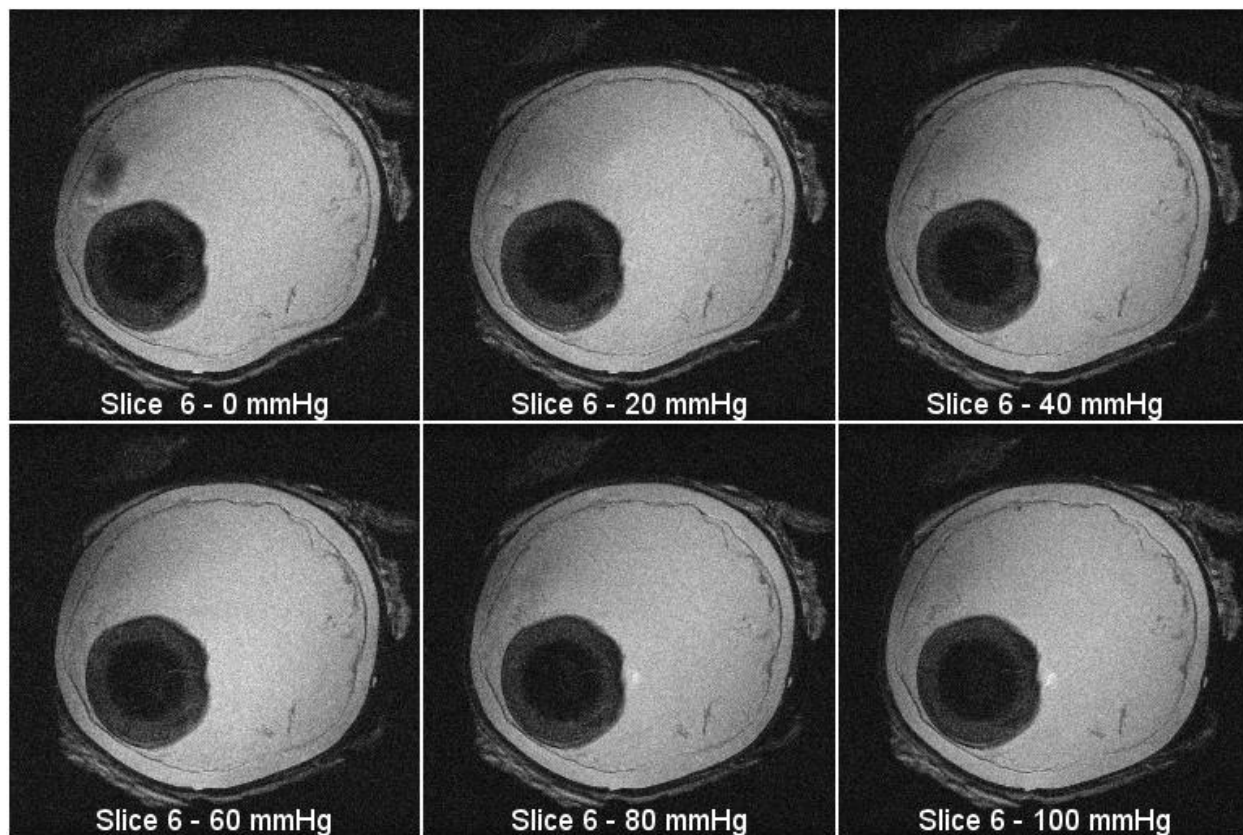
MRI Slice 6 from each pressure setting
